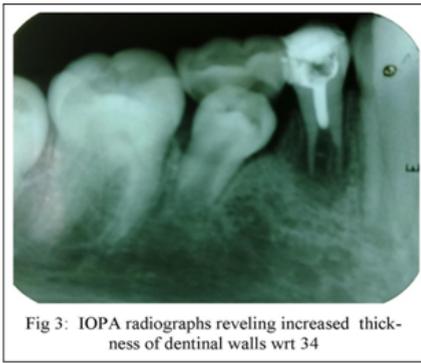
IOPA radiographs revealing increased thickness of dentinal walls wrt 34
